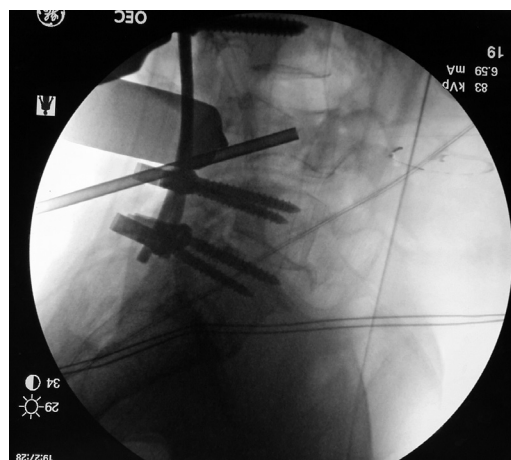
The operative radiograph shows autogenous iliac bone grafting with the help of a modified bone graft funnel.
